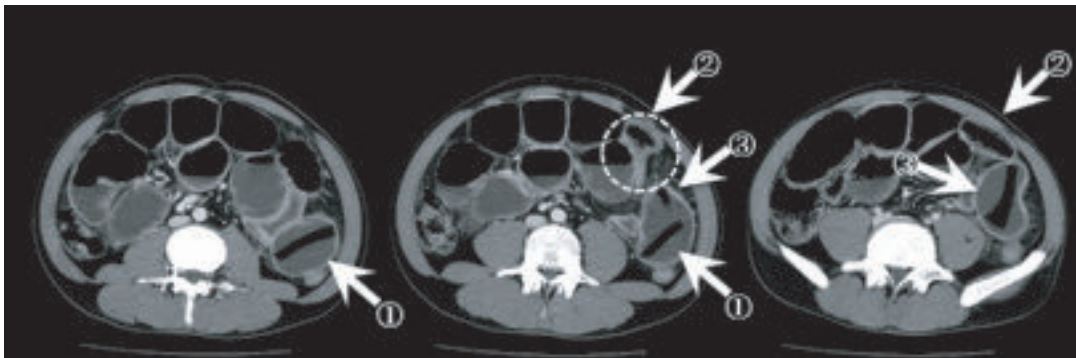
Abdominal CT showed a distended small intestine and 3 foreign bodies in the digestive tract (arrows) with caliber change (circle).
